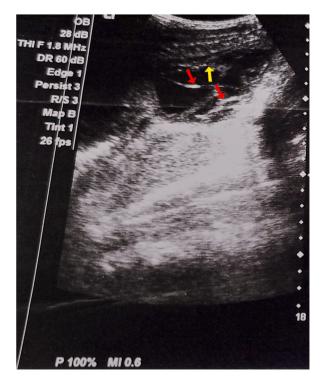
Chest ultrasonography (USG) image demonstrates multiple septations (red arrows) with thick parietal pleura (yellow arrow).
